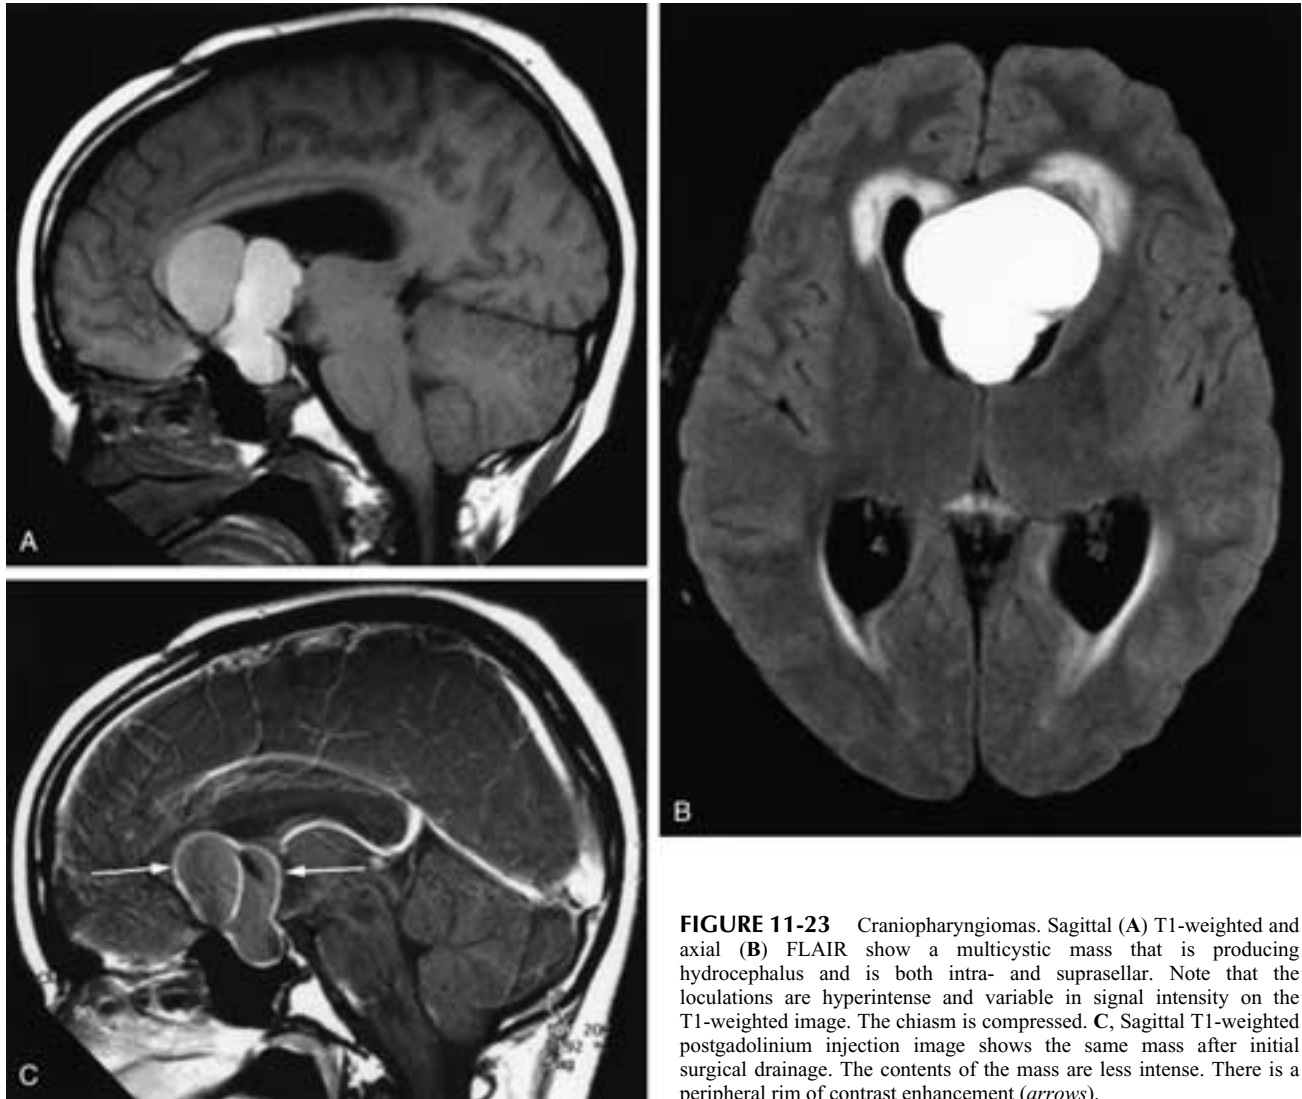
Craniopharyngiomas. Sagittal (A) T1-weighted and axial (B) FLAIR show a multicystic mass that is producing hydrocephalus and is both intra- and suprasellar. Note that the loculations are hyperintense and variable in signal intensity on the T1-weighted image. The chiasm is compressed. C, Sagittal T1-weighted postgadolinium injection image shows the same mass after initial surgical drainage. The contents of the mass are less intense. There is a peripheral rim of contrast enhancement (*arrows*).
